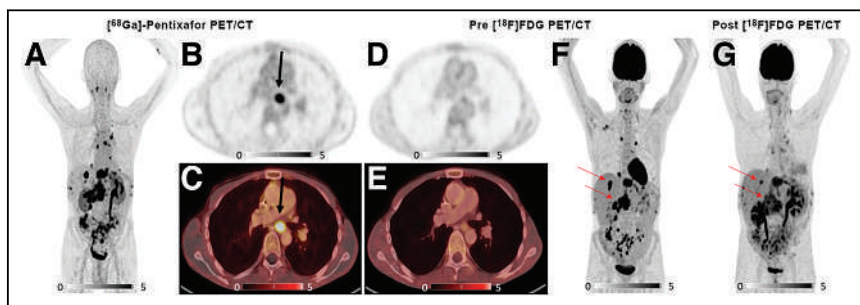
Pre- and posttherapeutic PET/CT scans with [⁶⁸Ga]pentixafor and [¹⁸F]FDG for patient 7. Shown are pretherapeutic coronal (A) and axial (B and C) slices of PET/CT scan with [⁶⁸Ga]pentixafor and corresponding slices using [¹⁸F]FDG (D–F). All metastatic lesions (lymph node, hepatic, and peritoneal implants) demonstrated intensive [⁶⁸Ga]pentixafor uptake with corresponding [¹⁸F]FDG accumulation (F), except for 1 lymph node metastasis in mediastinum (B and C, black arrows). Posttherapeutic [¹⁸F]FDG PET/CT shows significantly decreased metabolism of tumor lesions after [⁹⁰Y]pentixafor therapy (G, red arrows).
